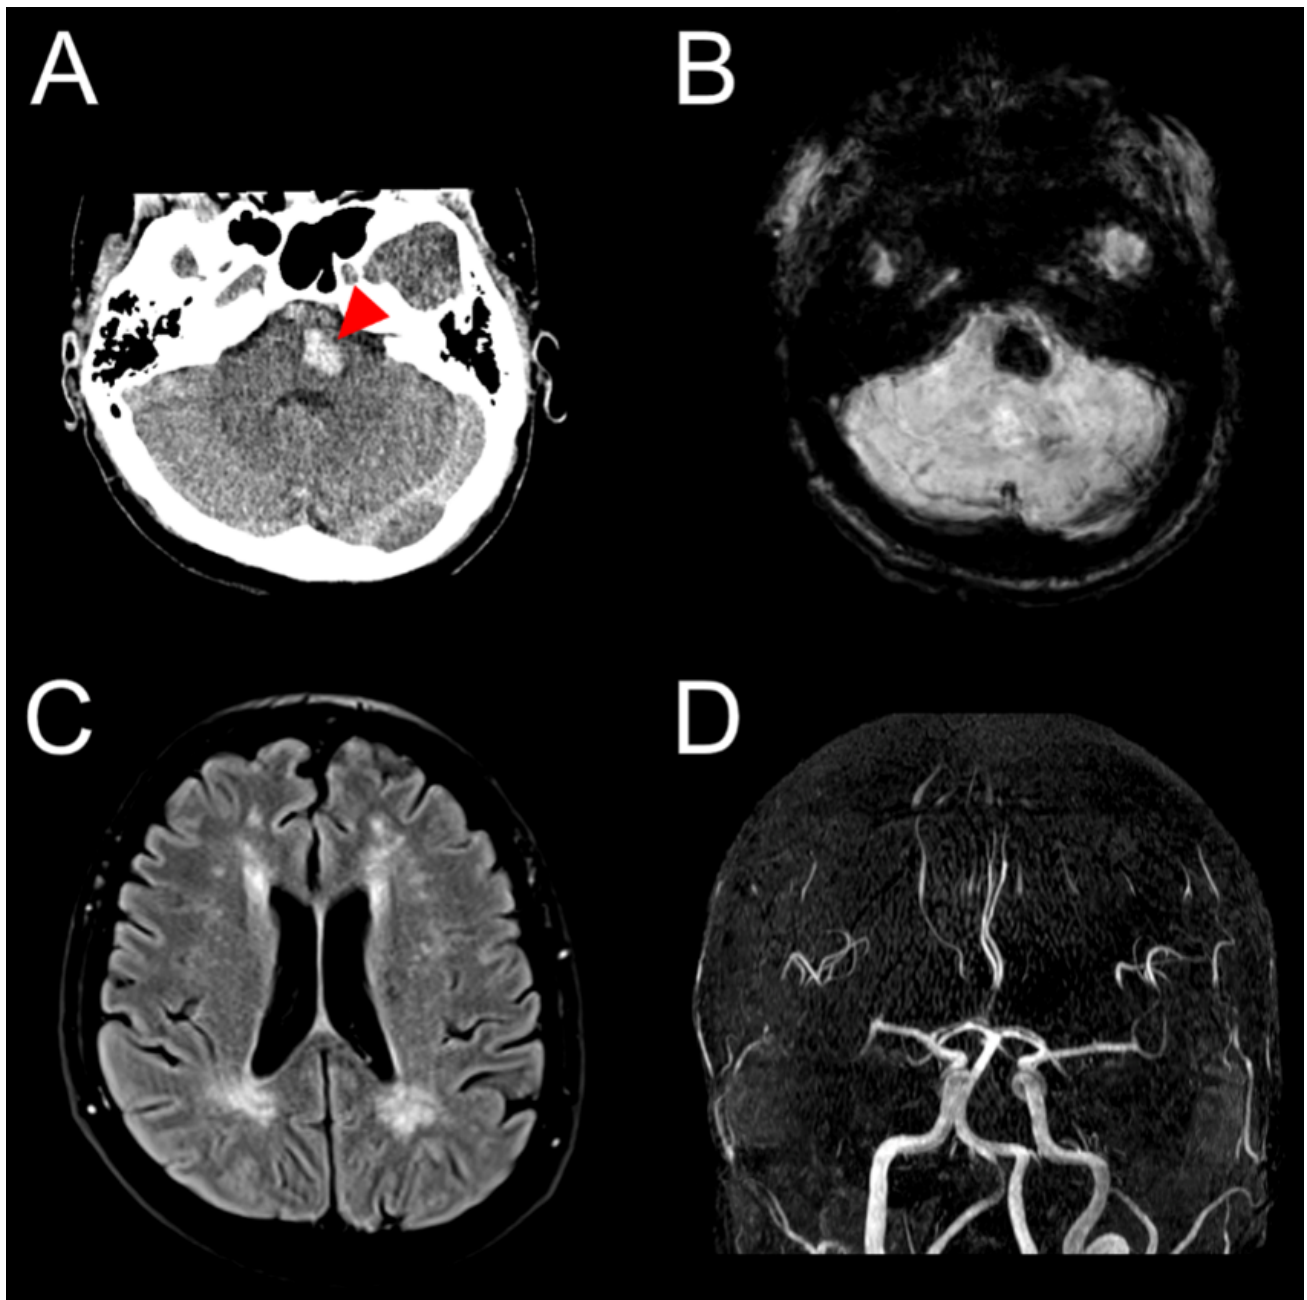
Acute CT, MRI and MRA sequences of patient in Case 1. An acute haematoma within the pons was shown on CT (A, red arrow) and susceptibility weighted imaging (B). Fluid-attenuated inversion recovery imaging showed confluent white matter hyperintensity that was consistent with a severe burden of small vessel disease (C). Tortuosity of the vertebrobasilar system on time-of-flight angiography indicated dolichoectasia (D).
